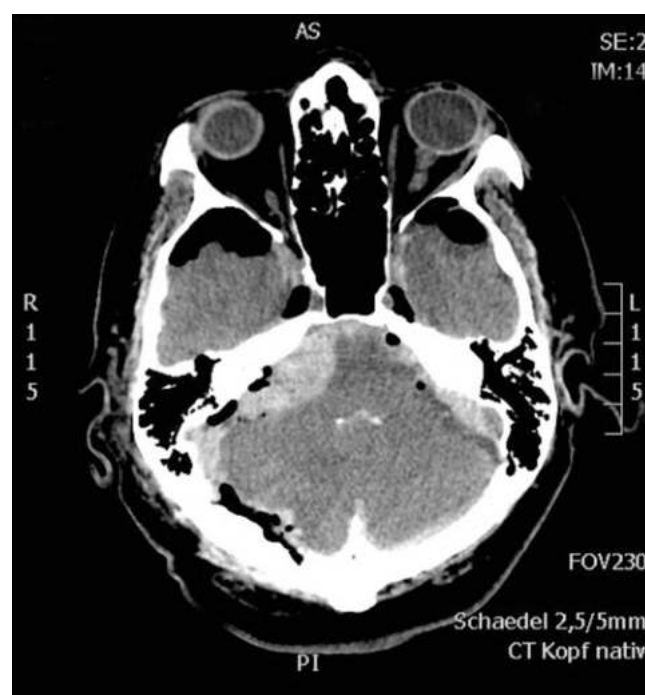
Postoperative CT scan showing a hematoma with resulting shift of the brainstem after an acoustic neurinoma resection
